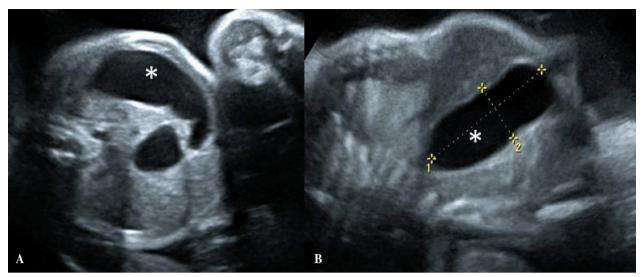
Prenatal ultrasonography at gestation week 32. A) Transverse cut demonstrating a double bubble image. B) Sagittal cut demonstrating a 57 x 22 mm gastric image (*gastric pouch).
